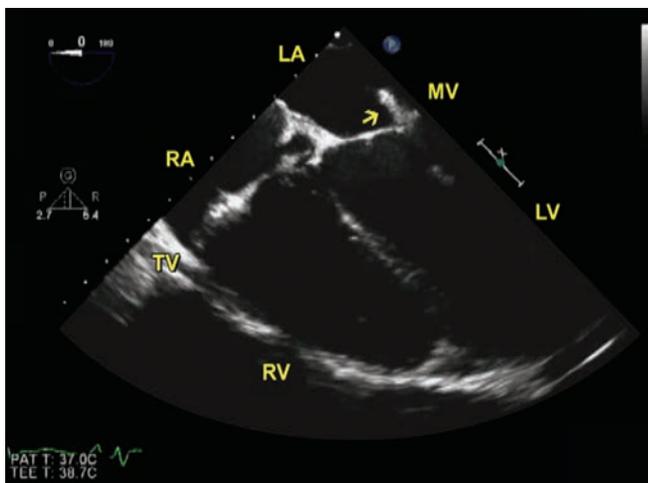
Transesophageal echocardiography. Arrow points to the lead going through the MV.
